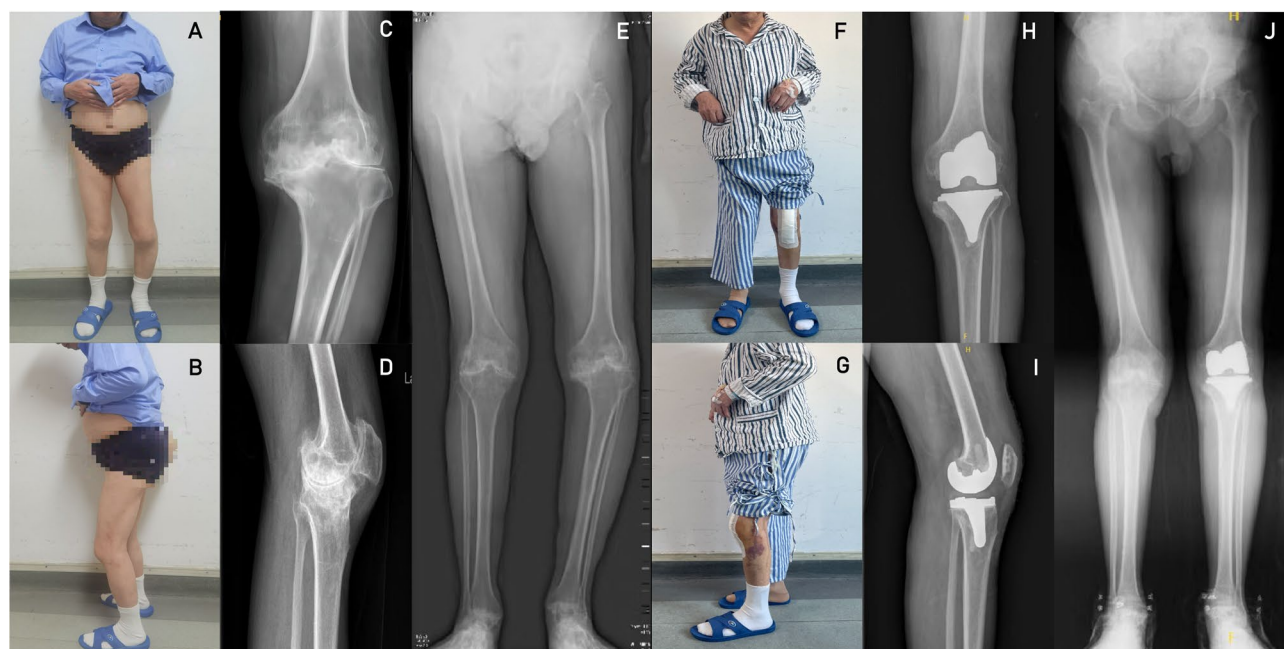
A male patient with advanced haemophilic knee arthropathy. The preoperative (A) Clinical anterior views; (B) Clinical lateral view (C) Anteroposterior radiograph; (D) Lateral radiograph; (E) Long-leg standing radiograph. The postoperative (F) Clinical anterior views; (G) Clinical lateral view (H) Anteroposterior radiograph; (I) Lateral radiograph; (J) Long-leg standing radiograph
